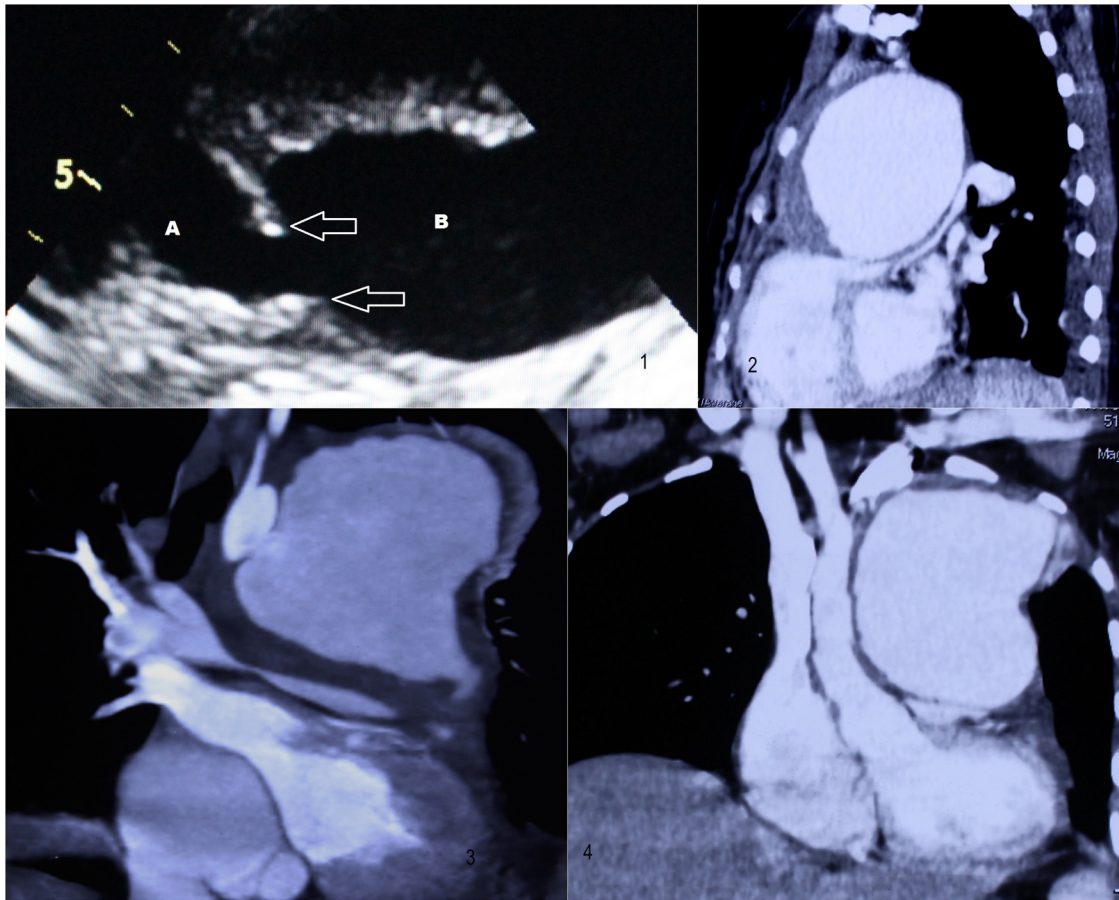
(1) Echocardiography showing communication between aorta (A) and pseudoaneurysm (B) with well-defined margins. (2) Computed tomography (CT) scan of thorax with contrast revealing large pseudoaneurysm arising from arch of aorta, extending anteriorly up to sternum. (3) CT scan of thorax with contrast revealing large pseudoaneurysm seen compressing main pulmonary and right pulmonary artery. (4) CT scan of thorax with contrast revealing large pseudoaneurysm arising from arch of aorta occupying left upper side of thorax.
